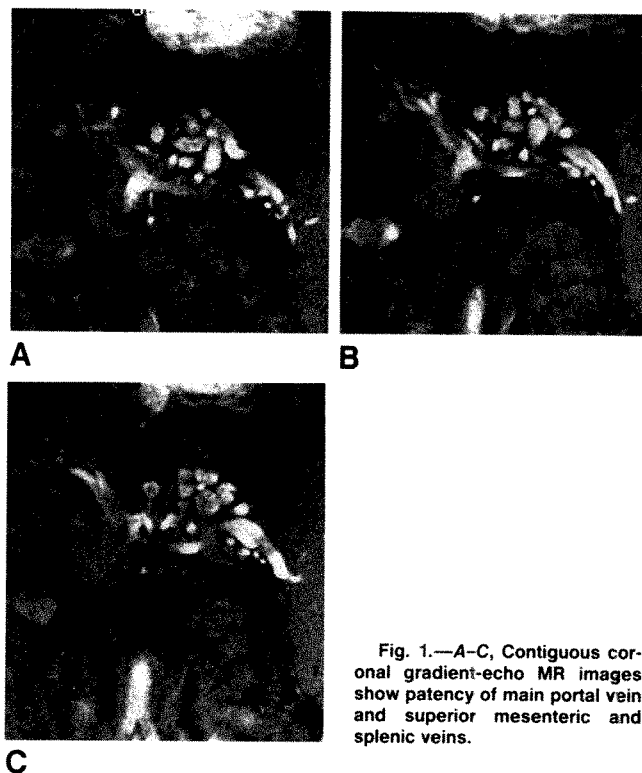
A-C, Contiguous coronal gradient-echo MR images show patency of main portal vein and superior mesenteric and splenic veins.
